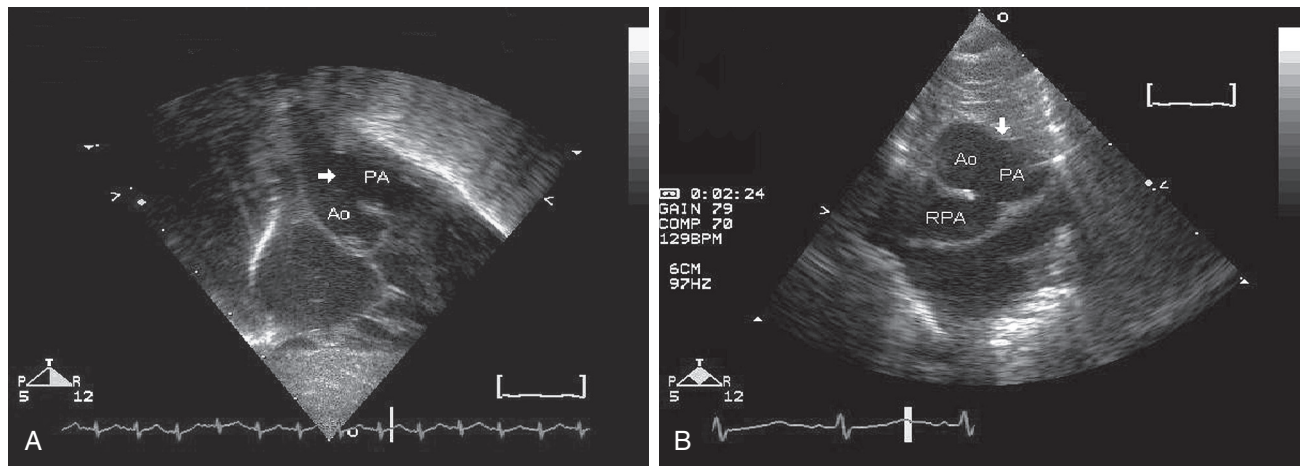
■ Echocardiographic views in a patient with a large (total-type) aortopulmonary window (as well as a type A interrupted aortic arch). A, Subcostal coronal view shows the large communication (arrow) between the ascending aorta (Ao) and the main pulmonary artery (PA). B, Parasternal short-axis view demonstrates that the distal extent of the aortopulmonary window involves the origin of the right pulmonary artery (RPA). The anterior border of the window is identified by the arrow.
